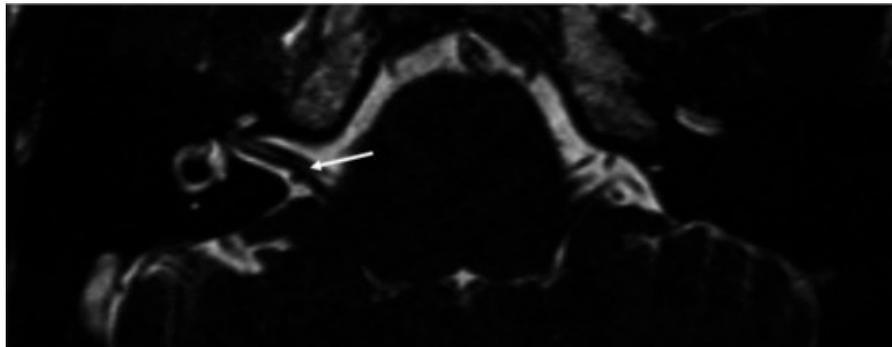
Heavily T2 weighted 3D CISS MRI sequence demonstrating an AICA loop, which contacts and causes angulation of the right vestibulocochlear nerve (arrowed).
